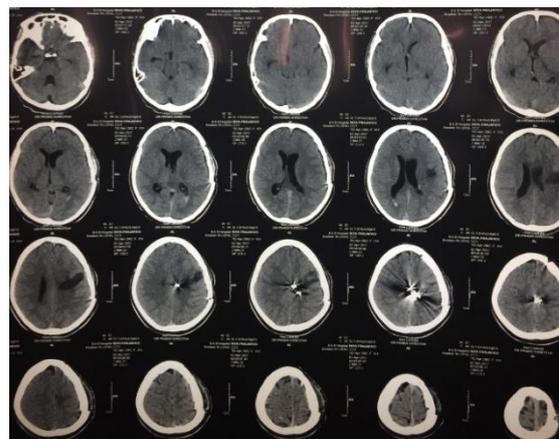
Postoperative CT scan of brain showing resection of AVM and clip artifacts in left frontoparietal area
